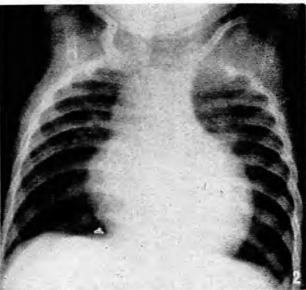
Cheryl X-ray of chest, showing left ventricular hypertrophy, enlargement of ascending aortic shadow, and well-marked pulmonary bay.
